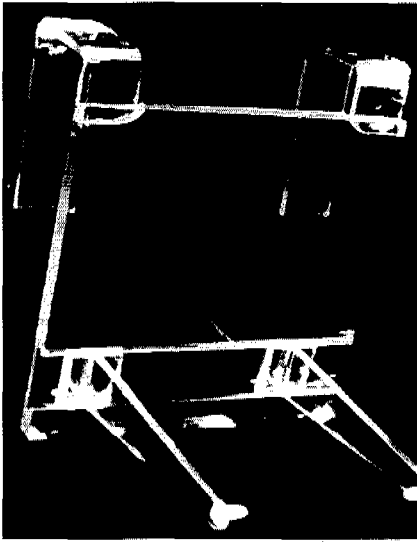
The cephalometer-like device had a base and two ear rods that consist of metal balls. The submentovertebral radiograph was taken with the subject's head supported by cephalometer-like device which we designed.
